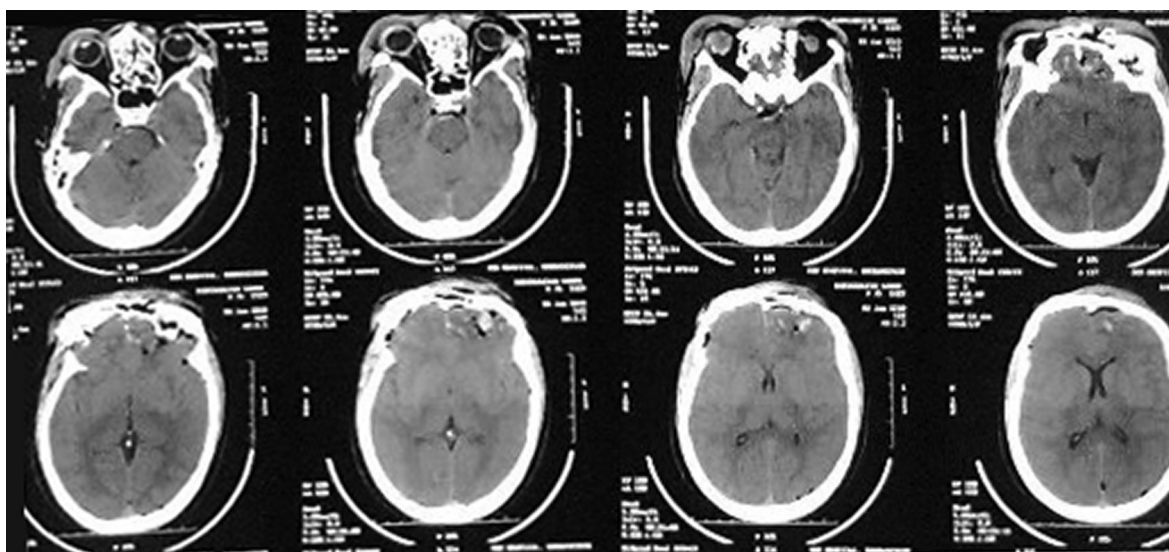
A plain CT head showing fracture of left frontal bone involving the sinus with mild depression of posterior wall of the sinus, underlying basi frontal small contusions and patchy pneumocephalus.
